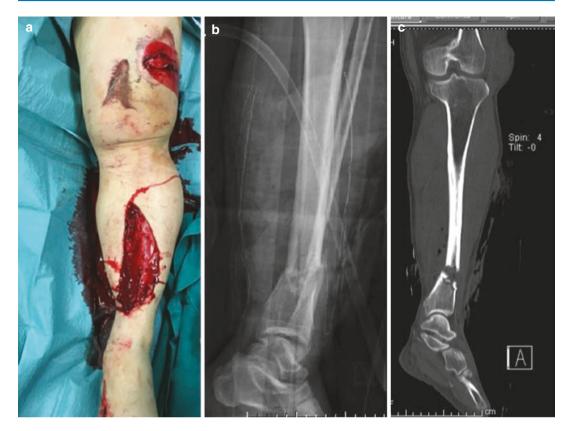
A 57-year-old patient is in the hospital after a motorbike accident. (a) Initial evaluation shows wounds of inferior left limb. (b) X-rays reveal tibial and peroneal fractures. (c) Confirmed by CT scan
